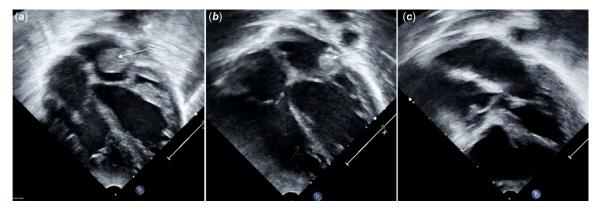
Echocardiographic images of patient 2. (a) Four-chamber view showing a large echogenic mass (inverted appendage) in the left atrium attached to the lateral wall. (b) Echocardiogram at 3-month follow-up showing a significant reduction in the size of the mass. (c) Complete resolution noted at 2-year follow-up.
